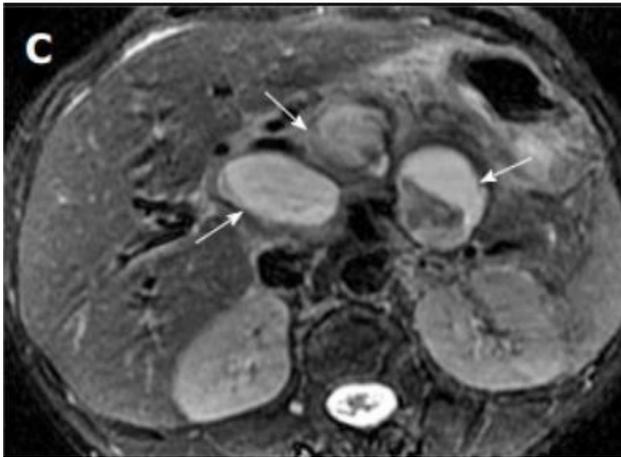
A 35-year-old patient with multiple cysts complicated by hemorrhage (acute pancreatitis in the nearest anamnesis). On T1-weighted images without contrasting (A, B) and T2-weighted image (C), white arrows indicate cystic formations with a non-uniform hyperecho signal, which speaks in favor of the blood contained in them
